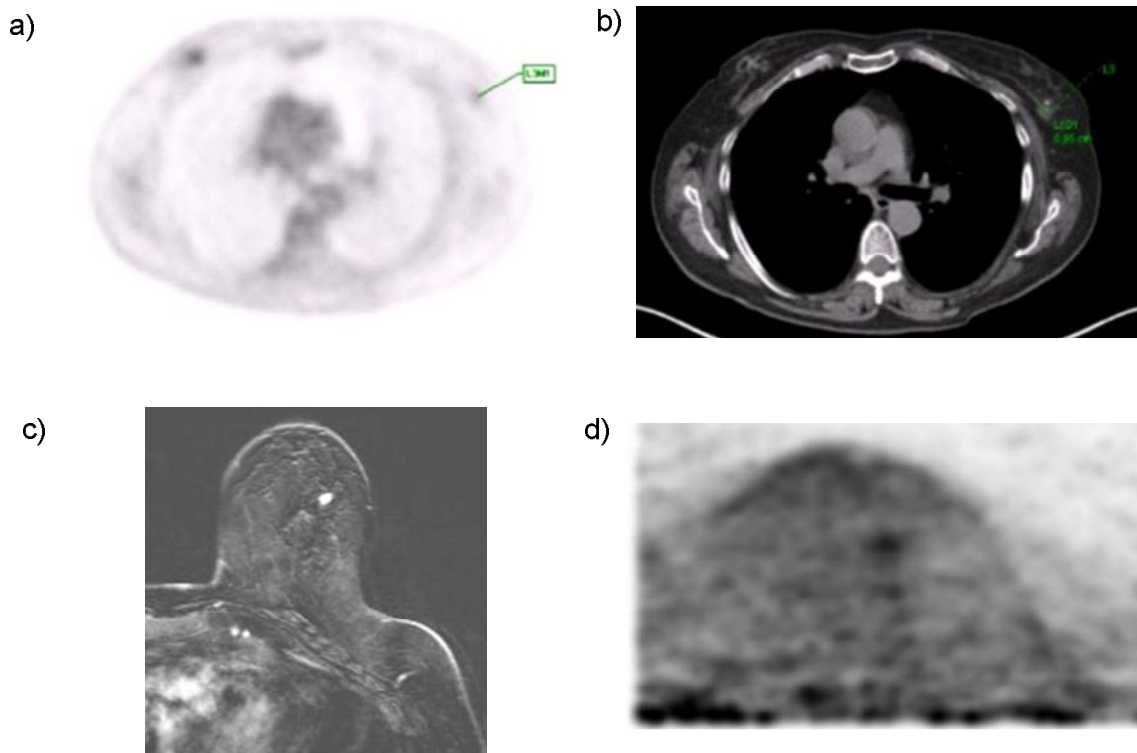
a) whole-body PET, b) CT, c) MRI and d) ClearPEM of the left breast of case 2
